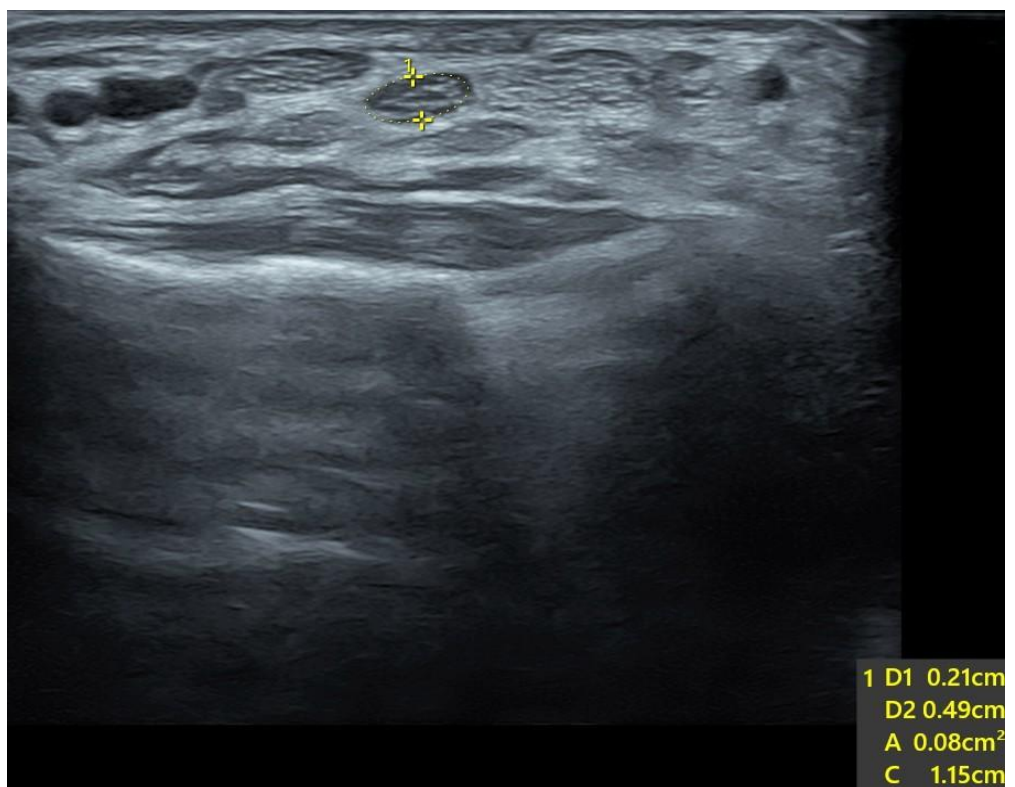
Ultrasound grey scale image, axial section showing C.S.A of median nerve - 0.08 cm² in a diabetic patient with neuropathy.
